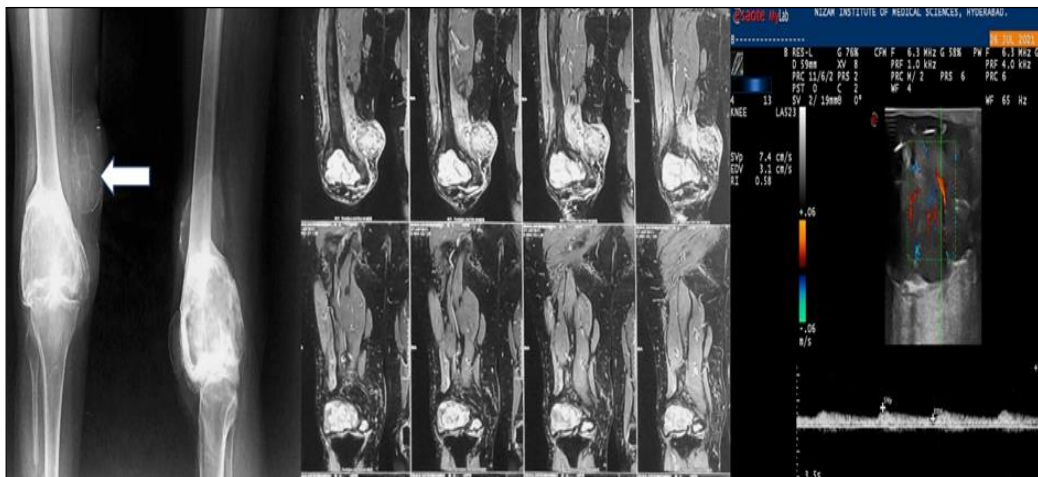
40/F Recurrence of operated GCT of lower end of femur with adjacent soft tissue deposit. Note: the deposit is having soap bubble appearance as indicated by arrow in the Radiograph
